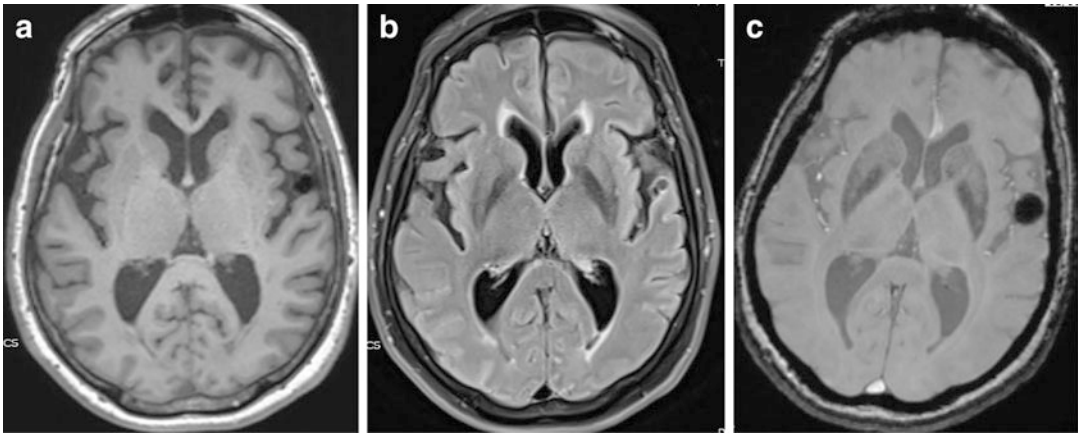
Follow-up MRI (T1WI (a), FLAIR (b), SWI (c)) obtained 6 months after the endovascular parent artery occlusion showed thrombosis of the target aneurysm with no sign of associated infarction
